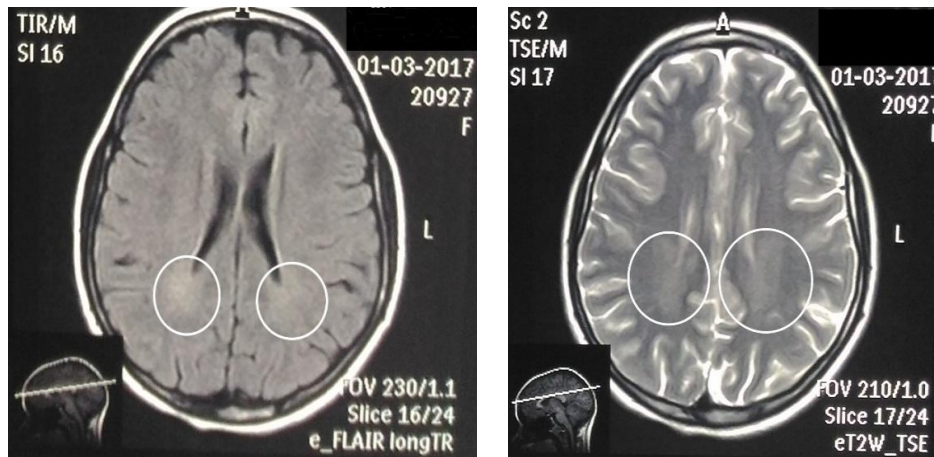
FLAIR and T2 weighted images of MRI brain showing areas of mild increased signal in parietal lobes, R > L
